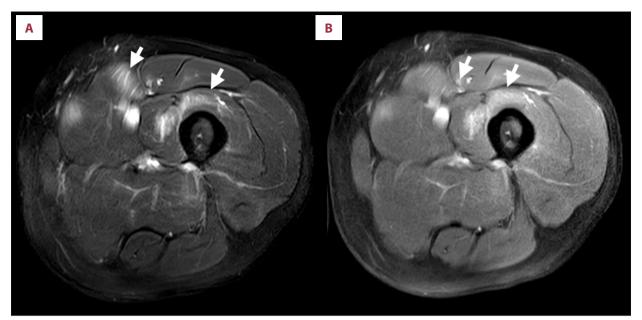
(A) T2-weighted fat-saturated sequence: axial image of the left thigh muscles showing areas of hyperintensity in the quadriceps and adductor muscles, in keeping with myositis. (B) T1-weighted fat-saturated post contrast sequence: coronal image of the left thigh muscles showing patchy enhancement corresponding with previously seen abnormal signal in the quadriceps and adductor muscles.
